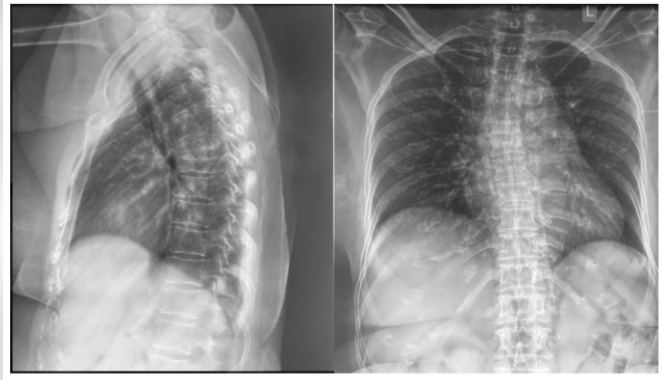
X-ray dorsal spine AP and Lateral showed endplate at opposing endplates of D5-D6 level with wedging of D5 and D6 vertebra
